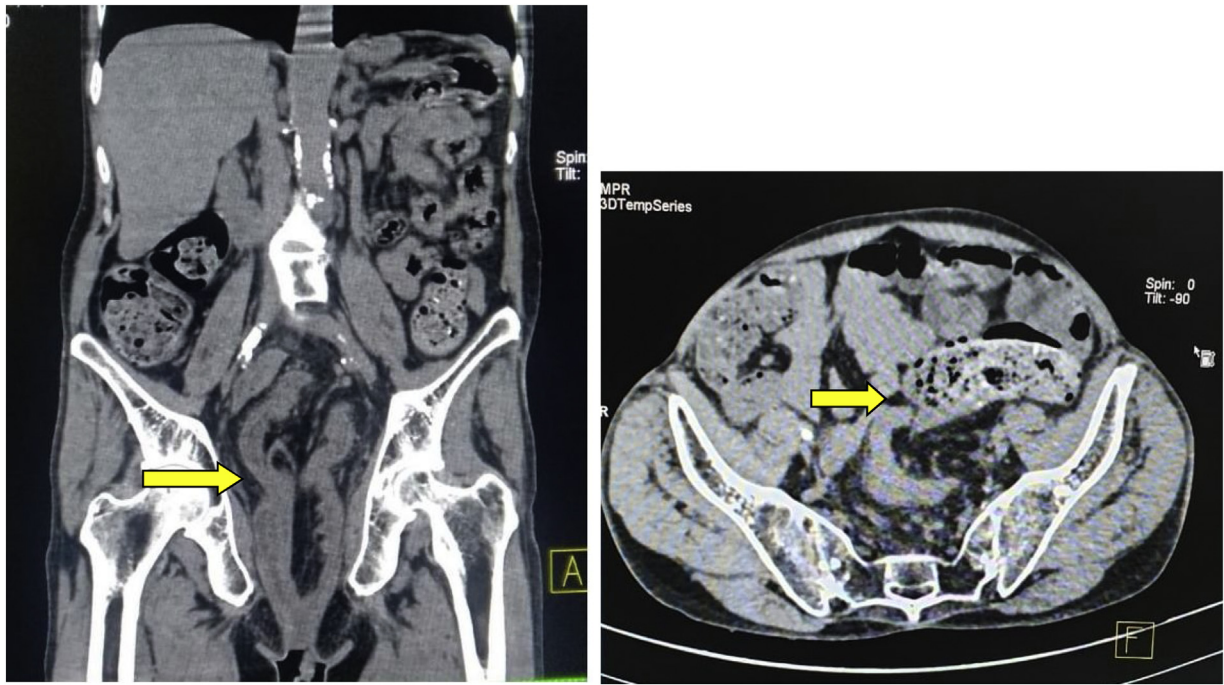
CT abdomen shows telescoping of the sigmoid colon into the rectum with probable lead point in the anal canal; No lymph nodes/ascites/metastasis.
